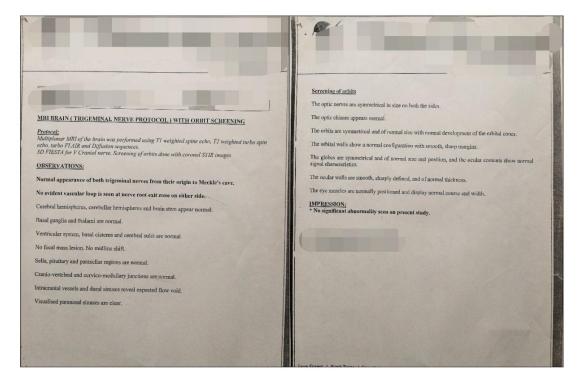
MRI report of brain
